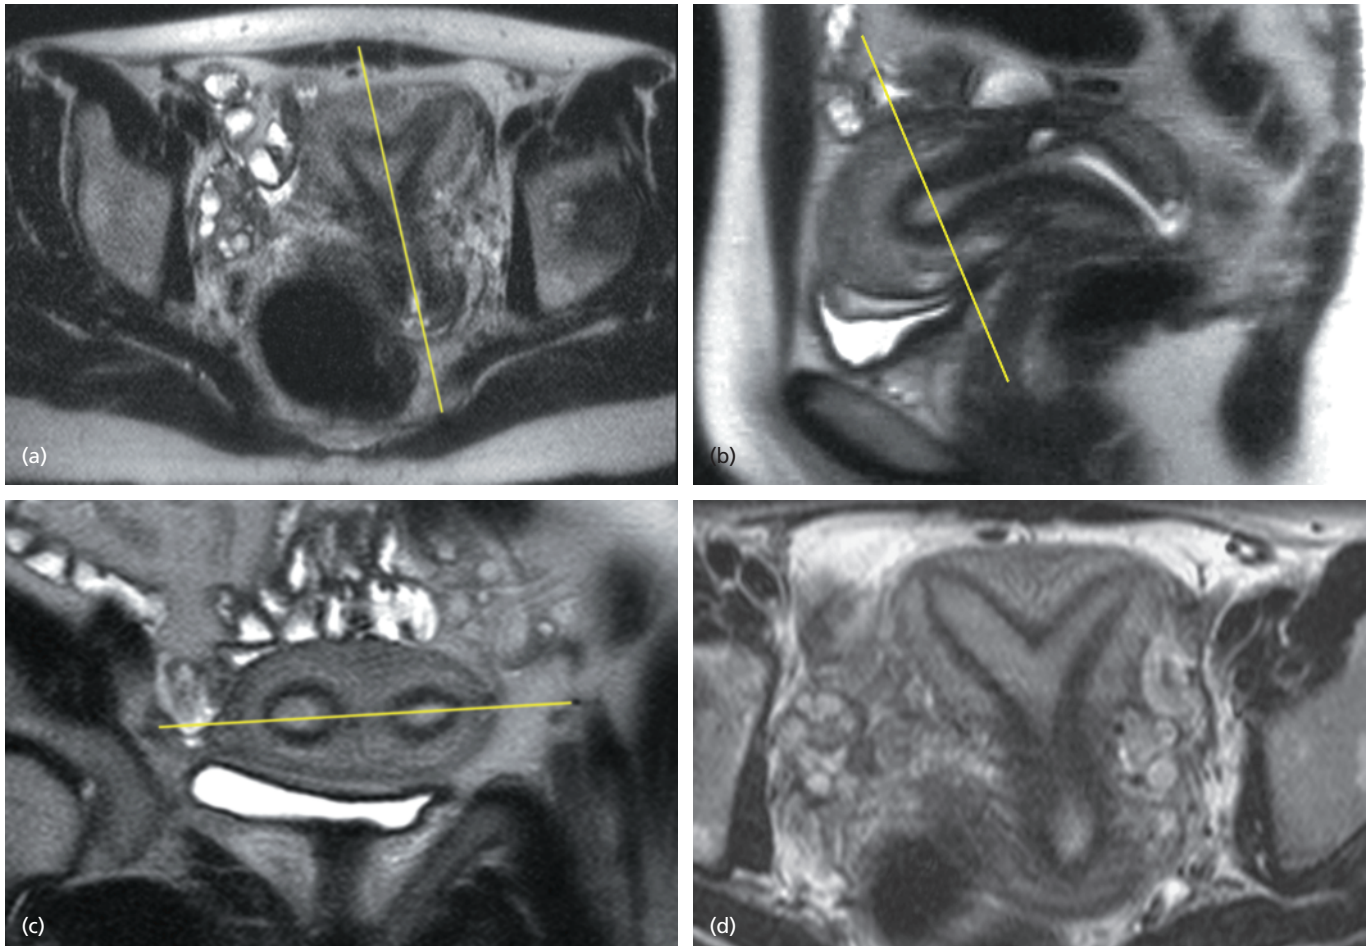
Imaging planes oriented to the uterus. Multiple T2-weighted images in a patient with septate uterus. Large field-of-view single-shot sequence (a) is obtained first and is used to plan an oblique sagittal T2-weighted sequence (b) obtained parallel to the endometrium (line, a). The oblique sagittal is used to plan an oblique axial (c) obtained perpendicular to the endometrium (line, b). The oblique axial may then be used to plan a true coronal of the uterus (d) obtained parallel to the endometrium (line, c). In the absence of 3D T2-weighted imaging, this process assures appropriate imaging planes regardless of angle/tilt of the uterus.
